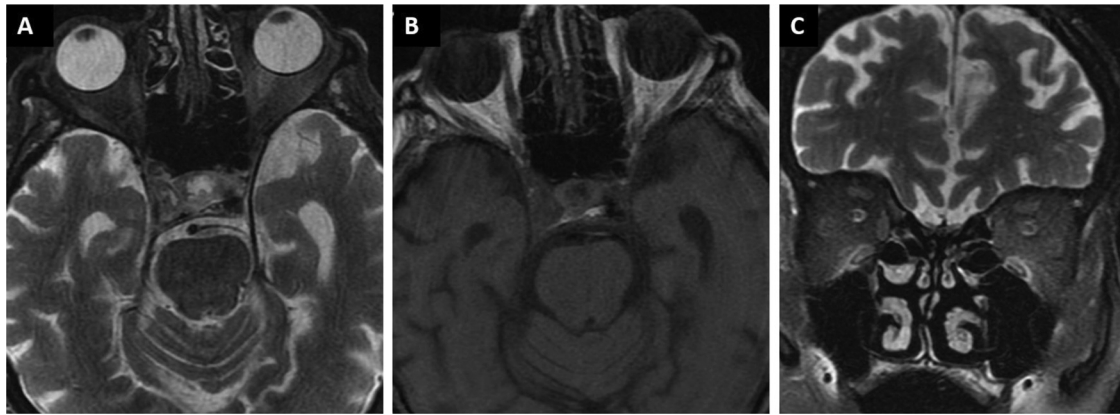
Follow-up MRI examination after 10 days, axial T2-weighted FATSAT (A), axial T1-weighted (B), and coronal T2-weighted FATSAT (C) images. The previously seen masses completely disappeared.
